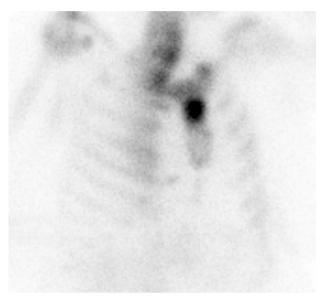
Whole body CT scan showing markedly increased activity of the sternum and milder patchy uptake of the thoracic spine.
